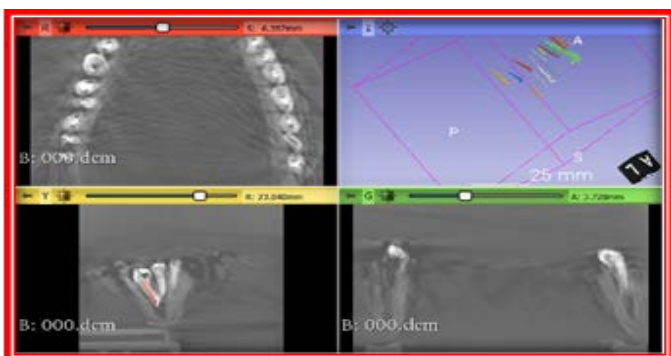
Volumetric CBCT analysis for samples
